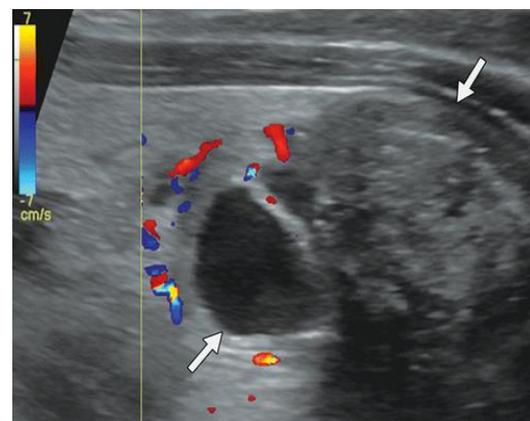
52 years old women who presented with thyroid nodule which on sagittal color doppler USG image shows 2cm mixed cystic and solid nodule in lower pole of left thyroid lobe. This image shows lack of colour flow within the nodule.
